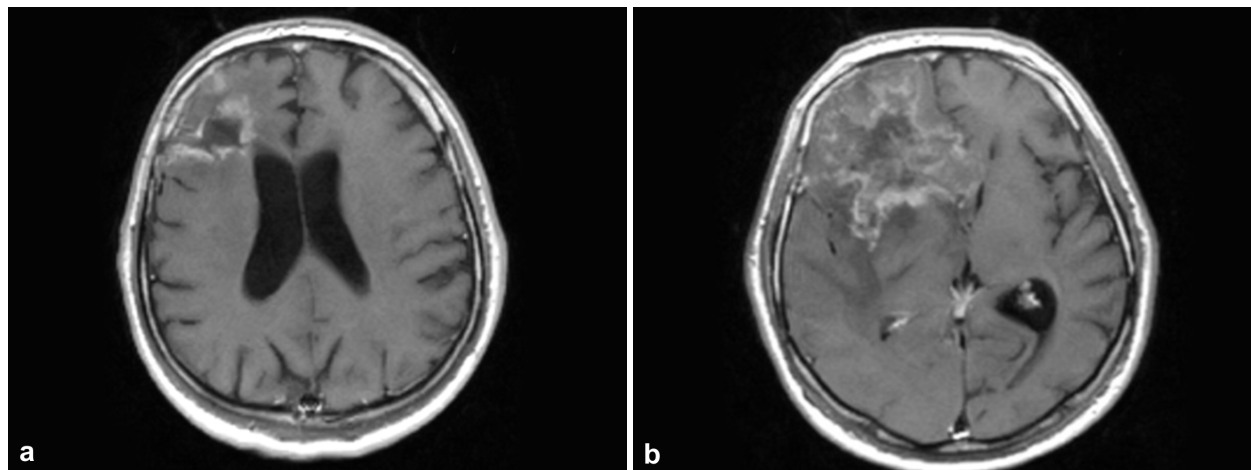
Brain MRI scan at 15 months (a) and 18 months (b) after the first intervention showed tumoral relapse and rapid growth.
